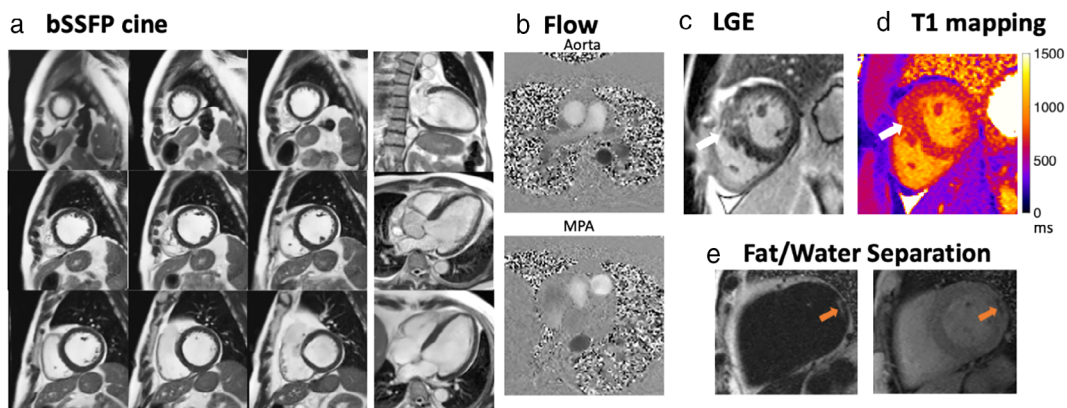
Example images from the prototype 0.55 T MRI system. (a) Free breathing bSSFP cine imaging of cardiac function using a compressed sensing image reconstruction (diastolic frame shown). This patient has a wall motion abnormality post myocardial infarction which can be seen in Video S1 in the Supplemental Material. (b) Flow quantification using phase-contrast MRI in the aorta and main pulmonary artery (MPA) in a patient with a ventricular septal defect. (c) Late gadolinium enhancement and (d) T1 mapping are shown in a patient with hypertrophic cardiomyopathy (white arrows). (e) Fat/water separation using the Dixon method in a patient with myocardial fat infiltration (orange arrows).
